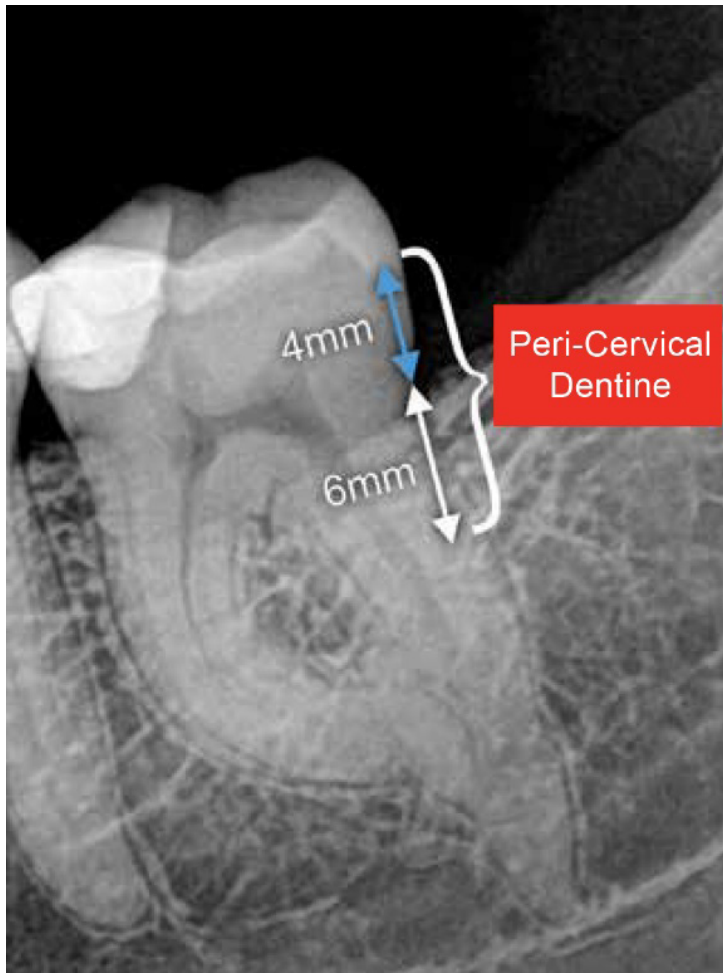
X-ray image showing the peri-cervical dentine.
